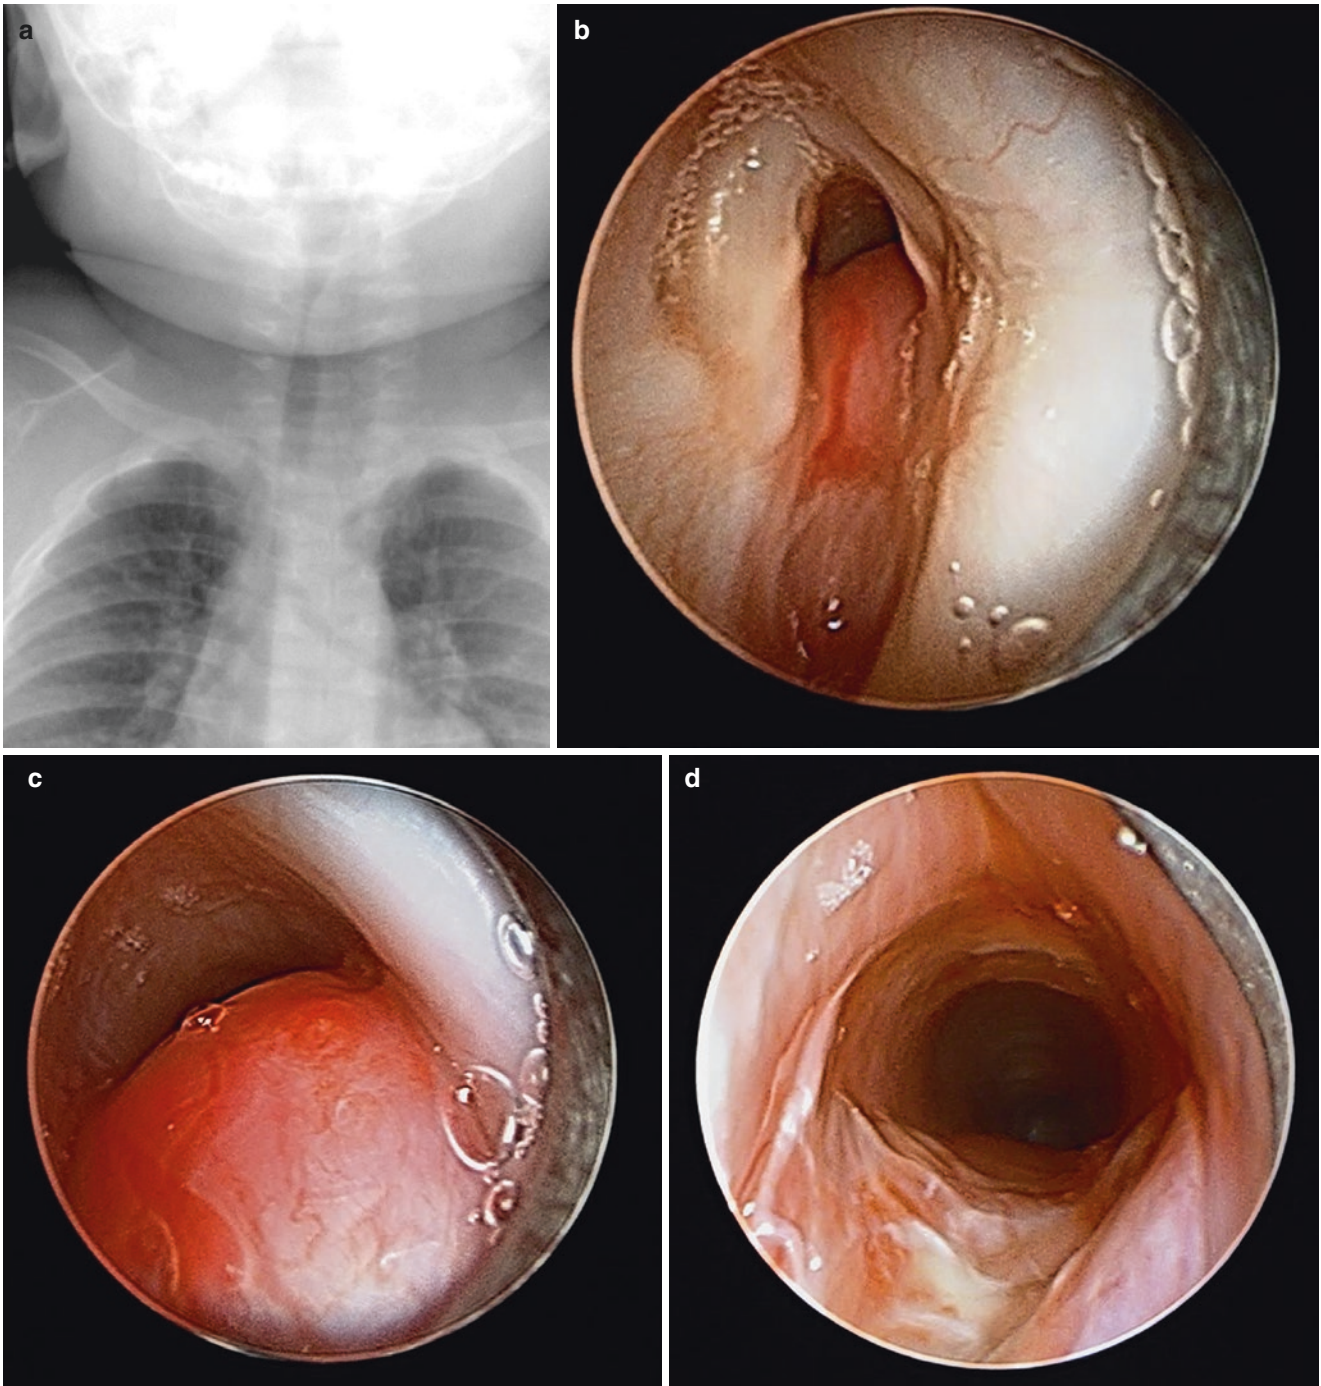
(a) Soft tissue radiograph of the neck shows an asymmetrical subglottic narrowing with soft tissue arising from the left side of the subglottis. (b) Subglottic hemangioma at presentation. (c) Subglottic
